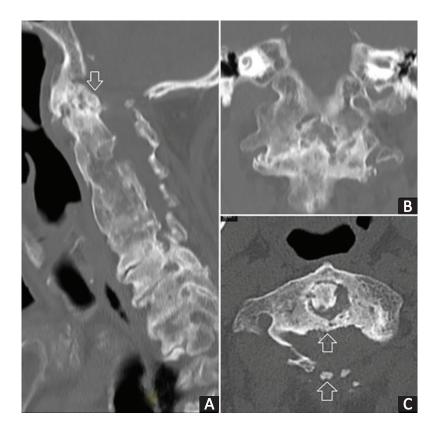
A: Sagittal computed tomography (CT) image showed atlantoaxial (C1–C2) fusion (arrow) in addition to previous C2–C6 fusion (arrow). B: Coronal CT image showed bilateral fusion of atlantoaxial joints. C: Axial CT image showed ossification of the transverse ligament of atlas (upper arrow) and a hypoplastic posterior arch with flecks of bone (lower arrow).
